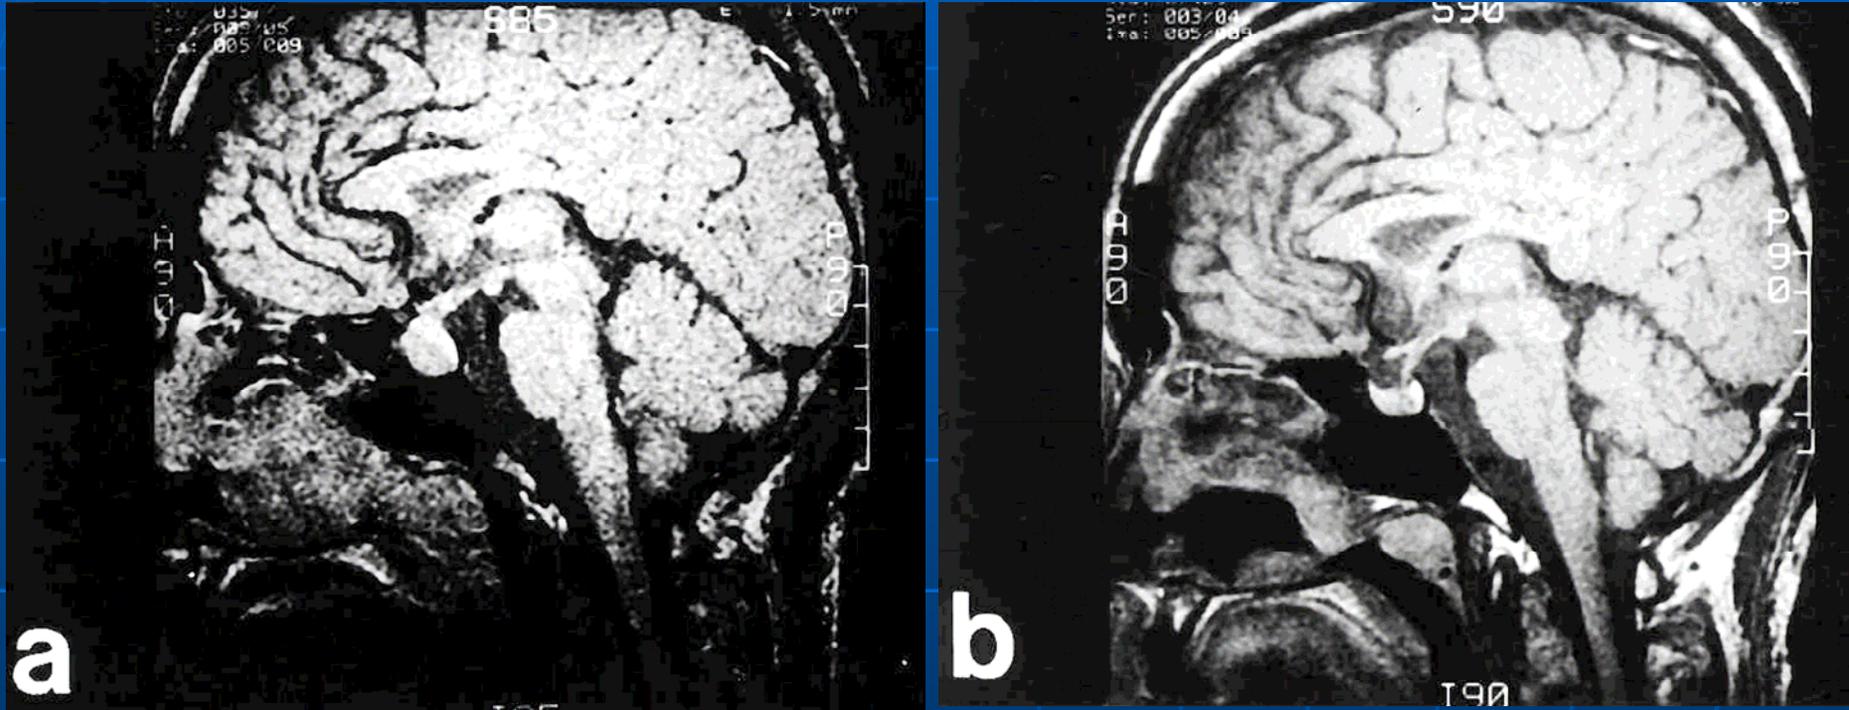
Brain MRI imaging: (a) before operation for pancreatic endocrine tumor, (b) one year after operation. Significant reduction of pituitary size is seen after the operation.
